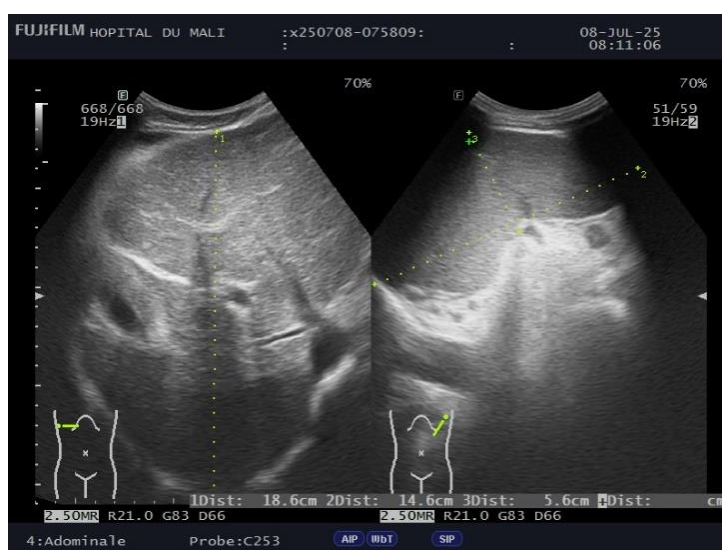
Coronal ultrasound of the liver showing hepatosplenomegaly.
